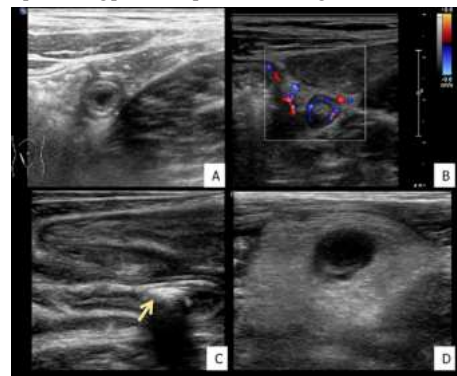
Spectrum of ultrasonographic findings in patients with acute appendicitis (A) Increased outer wall to wall diameter (8mm) (B) Increased vascularity in appendiceal wall on color doppler US. (C) Intraluminal appendicolith (yellow arrow) (D) Raised echogenicity of periappendiceal fat
